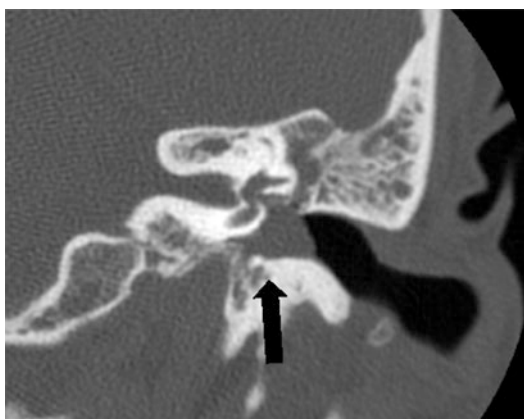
CT scan in a patient with a middle-ear neoplasm
